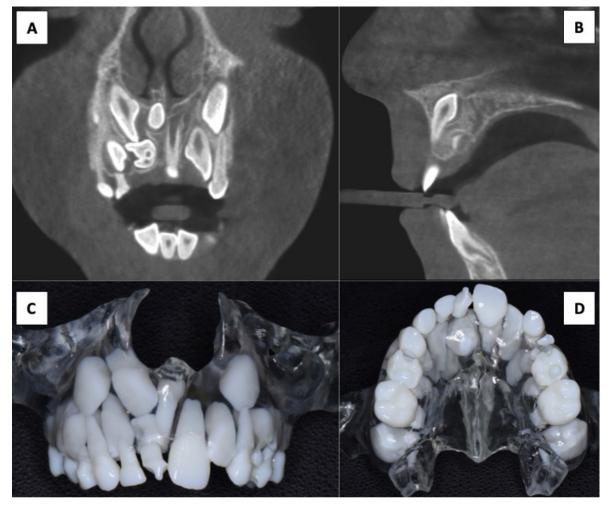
(A): Frontal CBCT cut showing impacted supernumerary and element 1.1; (B): CBCT sagittal cut showing mesiodens relation to ANS inside maxillary bone; (C): Stereolithographic model frontal view; (D): Stereolithographic model palatal view.
